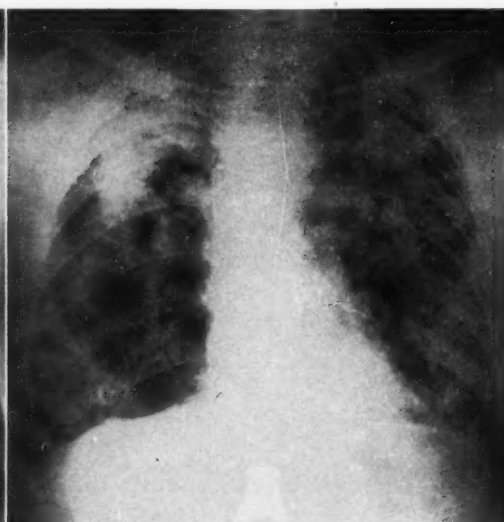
Case v. Roentgenogram of chest; full inspiration.
